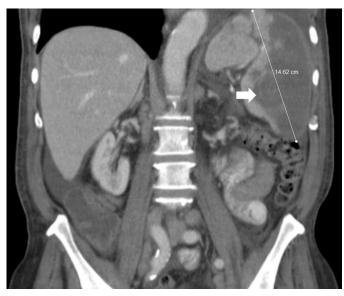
A 77 year old patient with chronic lymphocytic leukemia underwent splenic embolization through gastric collateral circulation. FINDING: Follow up CT scan, coronal reformatted image done 2 years after the procedure revealed marked decrease in the size of the spleen (14.6 cm) with multiple hypodense areas in its lower two-third (arrow) consistent with prior embolization. TECHNIQUE: mAs 201, kVp 100, slice thickness 4mm.
